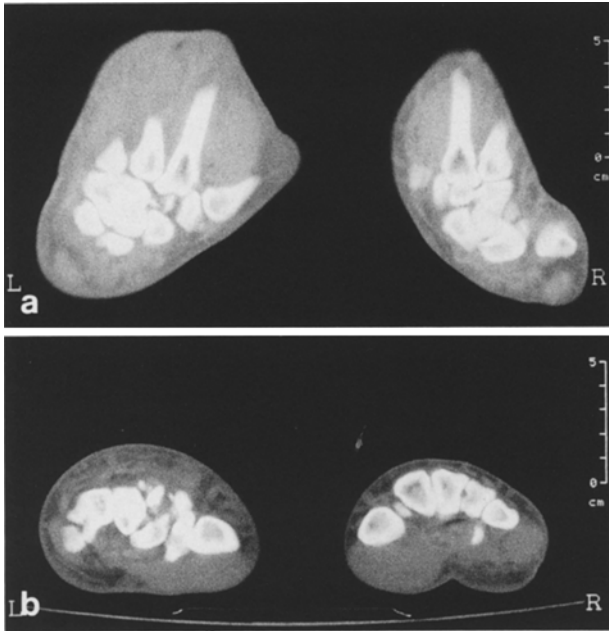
Pre-operative CT scan
